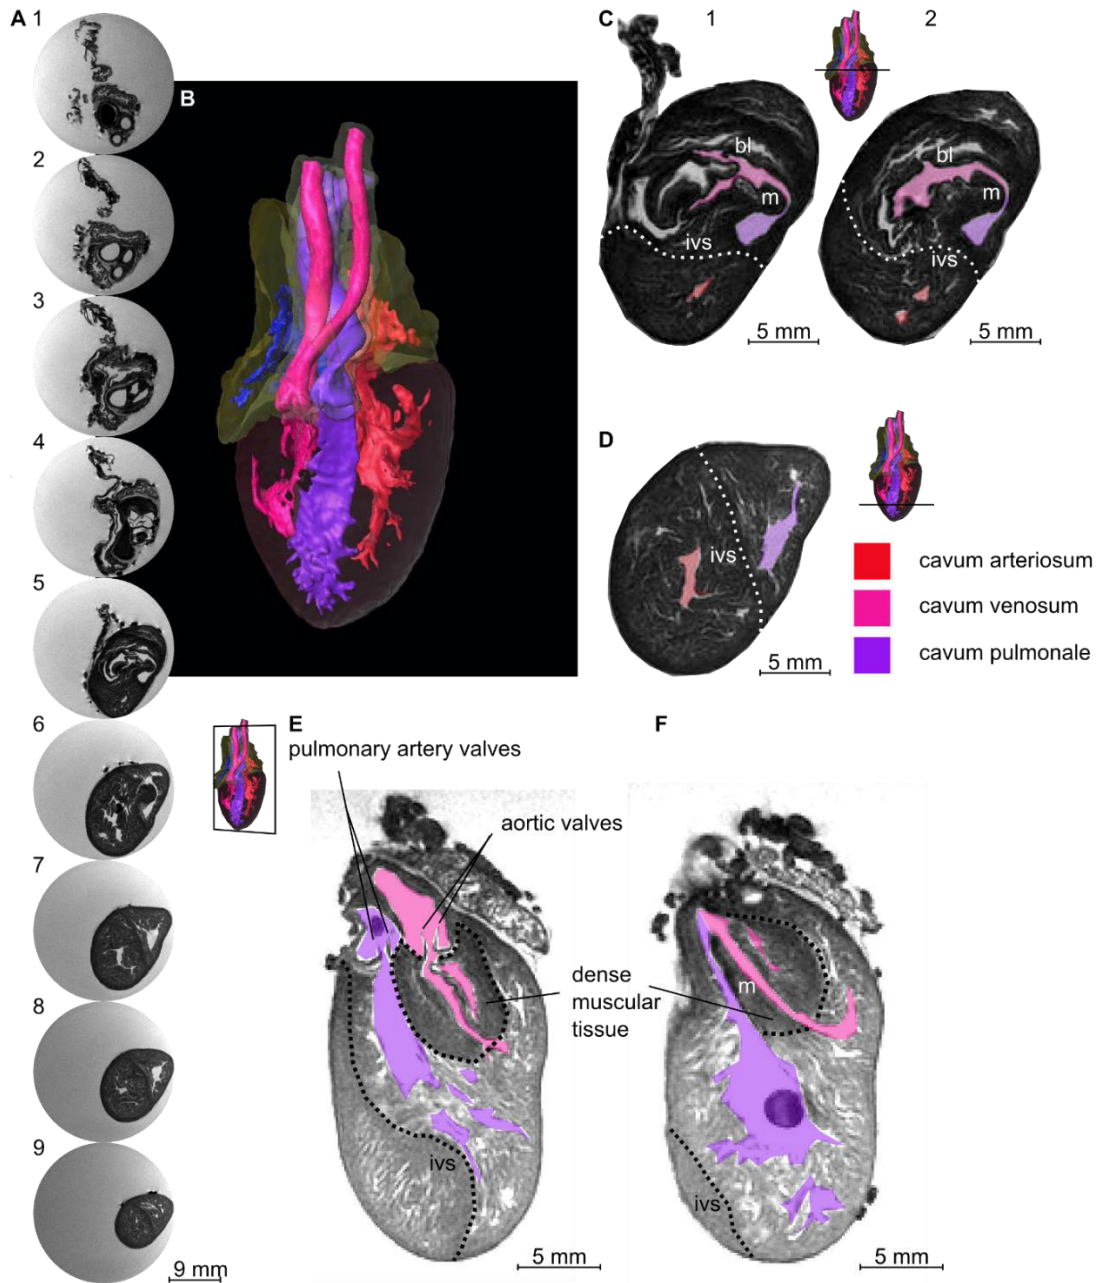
16: The heart of *Python molurus* examined with magnetic resonance imaging.
